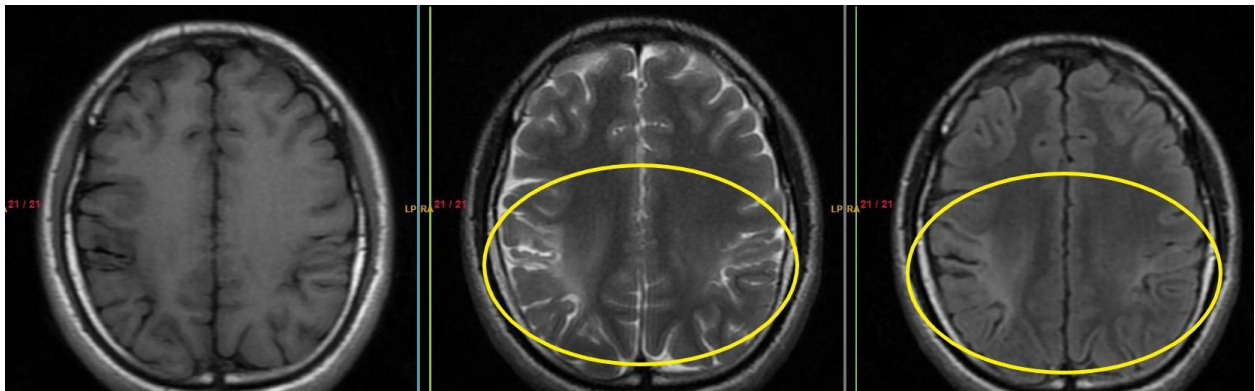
(A) Axial T1W image (left) (B) Axial T2W image (center) and (C) Axial FLAIR image (right) showing focal areas of cortical atrophy and thinning involving bilateral fronto-parietal regions with subcortical T2W and FLAIR hyperintense signal intensities.
